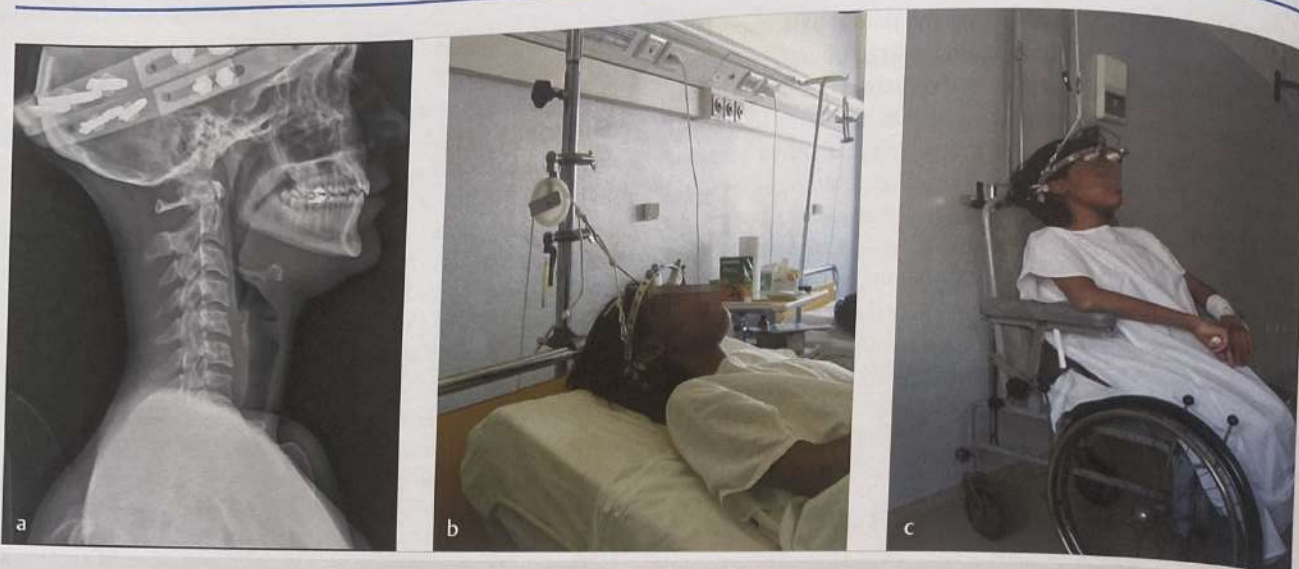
Halo-gravity traction. (a) X-ray of the cervical spine: possible overdistracted of the cervical spine must be avoided. (b) A girl in traction in bed and (c) in the wheelchair.
